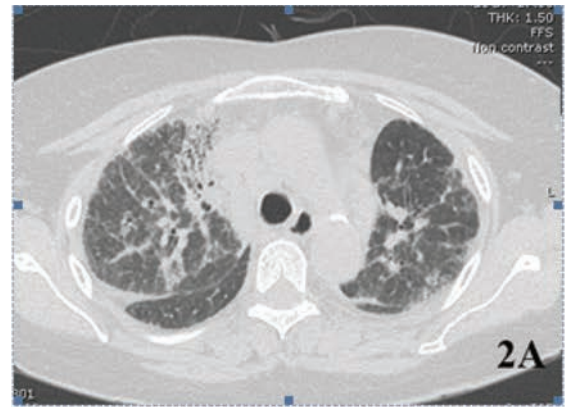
The serial axial CT scan of the chest (lung window) shows diffuse pulmonary fibrosis at upper (A), middle (B), and lower (C) lung zones. Honeycombing lung is also demonstrated at the peripheral aspect of the right middle lobe (B, arrows).
